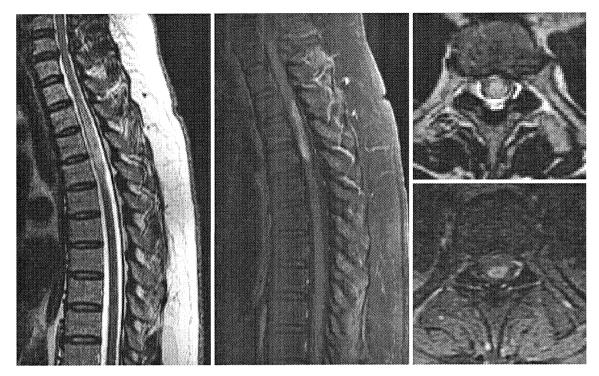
Spinal magnetic resonance imaging (MRI) of patient 2: T2-weighted image (1.5 T, repetition time [TR] 3000 ms, echo time [TE] 90 ms) and T1-weighted image with gadolinium enhancement (1.5 T, TR 400 ms, TE 9 ms). When patient 2 had her last relapse at age 49, the spinal MRI scan showed high-intensity areas at Th2-4 on T2-weighted images with swelling and gadolinium enhancement.
